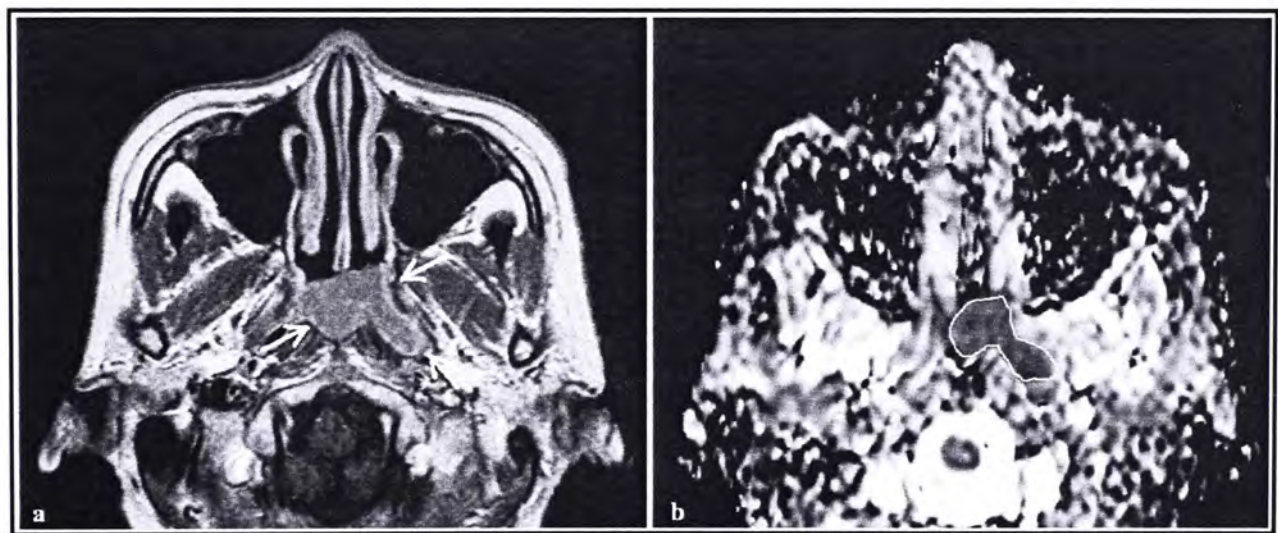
Post-contrast T1-weighted image (left) with the primary NPC (arrows) and ADC map (right) with the region of interest drawn around the primary NPC.
